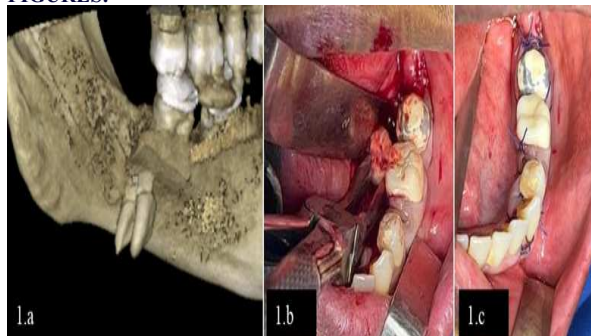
Pre-operative and intra-operative images (a) CBCT depicting buccally angulated 38 positioned in the soft tissue lingual to the angle of mandible with laterally placed crown and root facing medially; (b) Blunt dissection done intraorally and retrieval of the tooth was carried out uneventfully using specialized root retrieval forceps; (c) Primary closure was achieved using 3-0 Vicryl sutures in a sling fashion.
